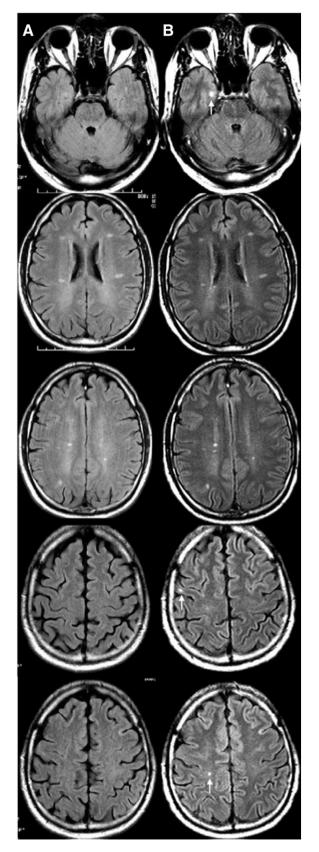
MRI of the brain (A) Axial FLAIR sequences from November 2010 showing 8 small hyperintense foci and (B) Axial FLAIR sequences from March 2011 showing interval development of new hyperintense lesions (*marked with white arrows*).
